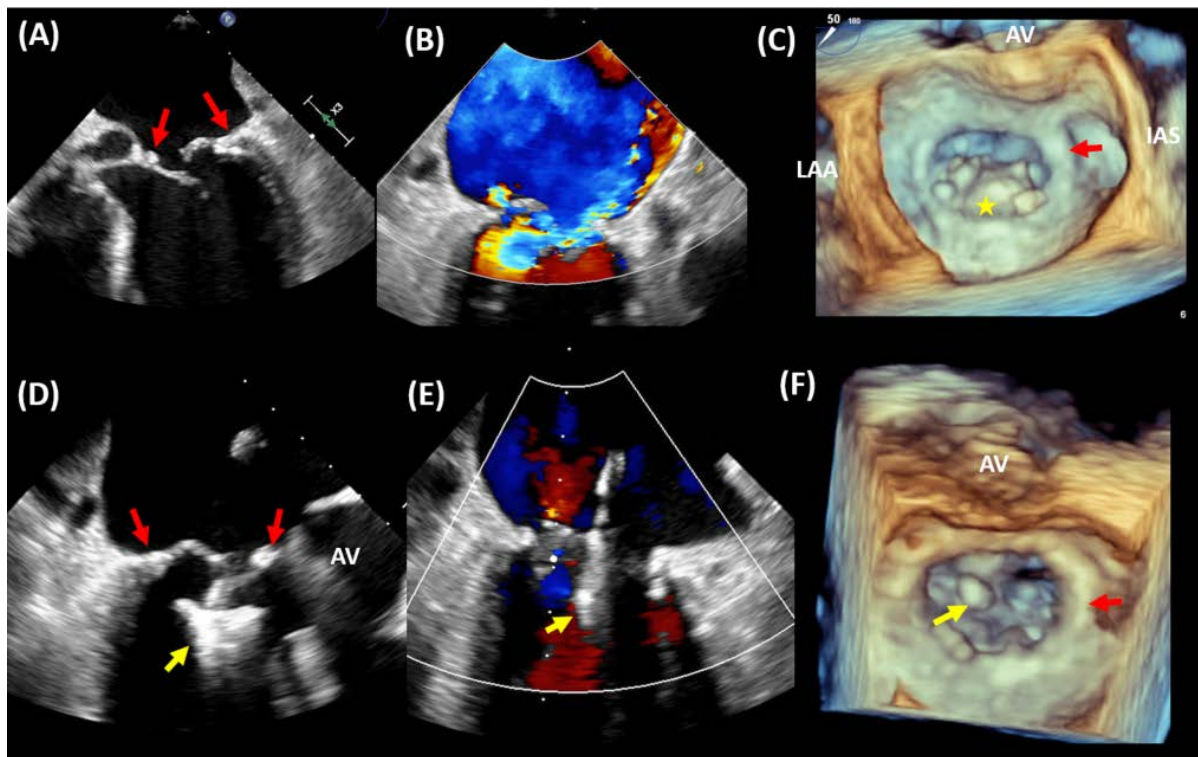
MitraClip in annuloplasty ring. A case of transcatheter edge-to-edge repair (TEER) in a patient with a surgical mitral valve ring (MVR). (A) Transesophageal echocardiography (TEE) showing a prolapsed posterior leaflet within the MVR (red arrow) resulting in severe eccentric MR (B). 3D TEE imaging demonstrating prolapsed posterior leaflet (*) within the MVR (C). The patient underwent TEER with MitraClip device (yellow arrow) implantation at A2-P2 (D) resulting in mild residual MR (E). 3D TEE imaging demonstrating the location of the MitraClip at A2-P2 in relation to the MVR (F). AV, aortic valve; LAA, left atrial appendage; IAS, interatrial septum.
